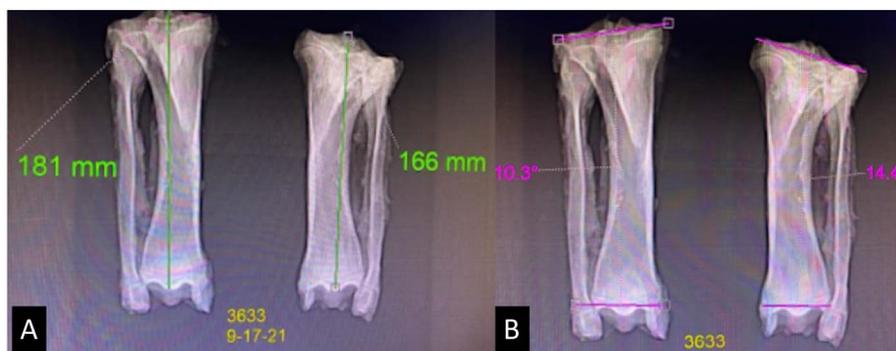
CT scan at time of euthanasia allowed us to measure the differences in (A) length and (B) angulation between the control tibia (left) and experimental tibia (right). Tibial length measurements were taken proximally from between the tibial eminences and distally to the tibial plafond. A color image accompanies the online version of this article.
